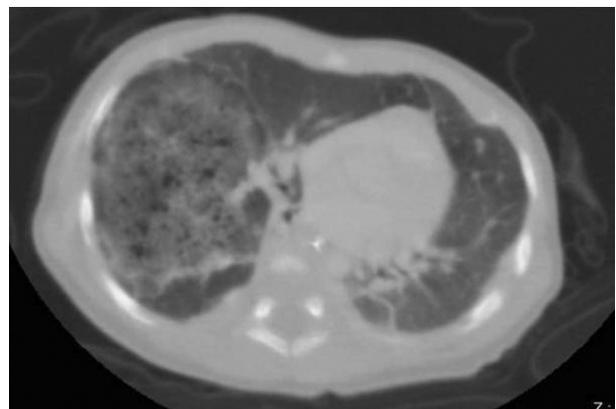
Second contrast-enhanced computed tomography scan; multiple small cystic filled with air in the middle lobe of the lung and position of the heart was normal
